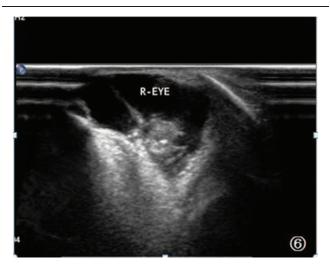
Postnatal 2-dimensional ultrasound image of the right eye: the shape of the right eye is abnormal, and a crystalline lens cannot be observed in the orbit.
